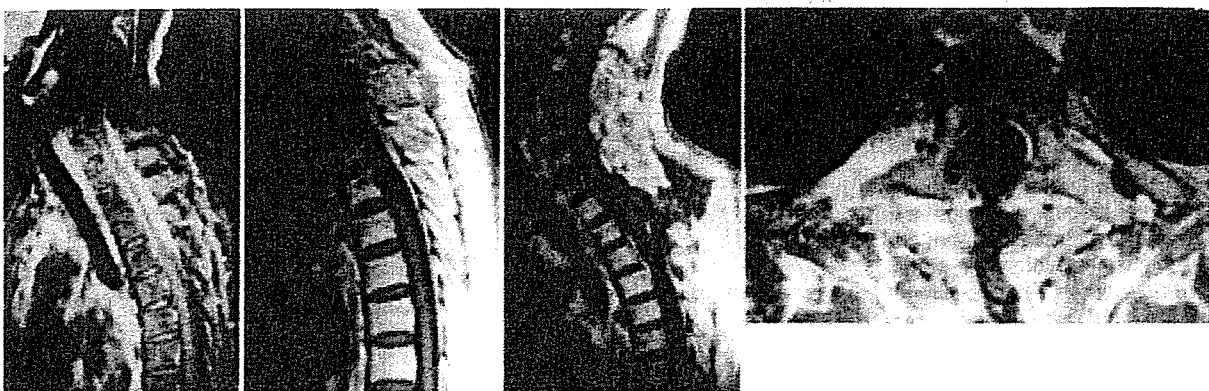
Case 2. Magnetic resonance images. A: Sagittal Gd-enhanced sequence, revealing HSP at the T1–5 level in the dorsal and ventral dura mater. B: Sagittal Gd-enhanced sequence, showing the same HSP lesion after steroid therapy. C: Sagittal Gd-enhanced sequence obtained after surgery, showing that virtually all of the thickened dura had been removed. D: Axial Gd-enhanced sequence obtained after surgery, demonstrating no dural thickening.
